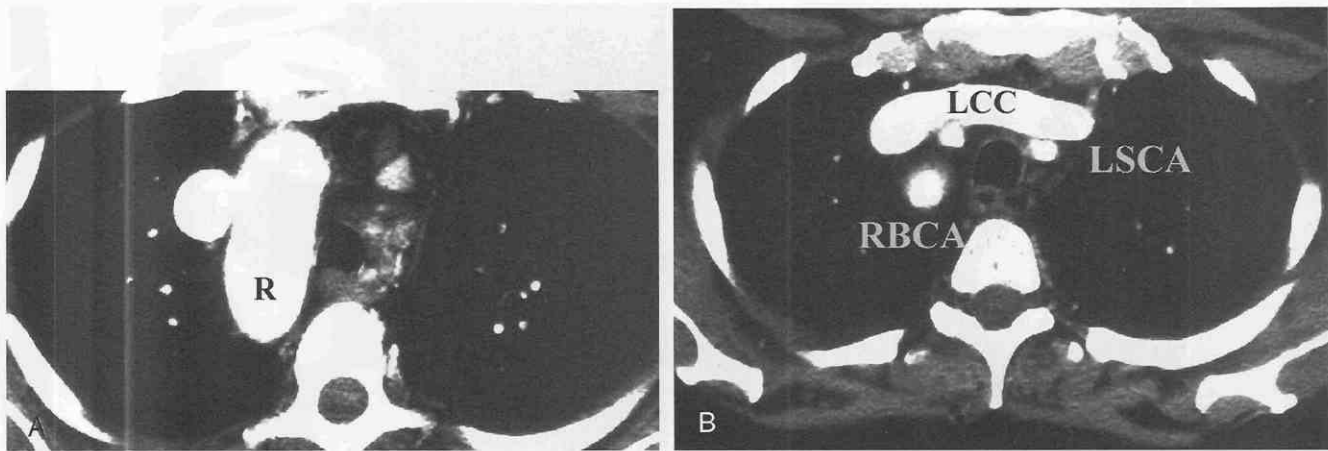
A, Axial CT scan shows the right aortic arch (R). There is no evidence of an aberrant subclavian artery. B, In the same patient, an axial CT scan superior to A shows the right brachiocephalic artery (RBCA), the left common carotid artery (LCC), and the left subclavian artery (LSCA), consistent with a normal left aortic arch branching pattern.
